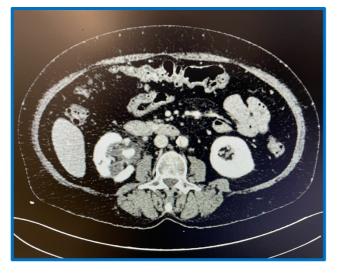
CT scan: obstructive stone in the right renal pelvis; secondary hydronephrosis.
